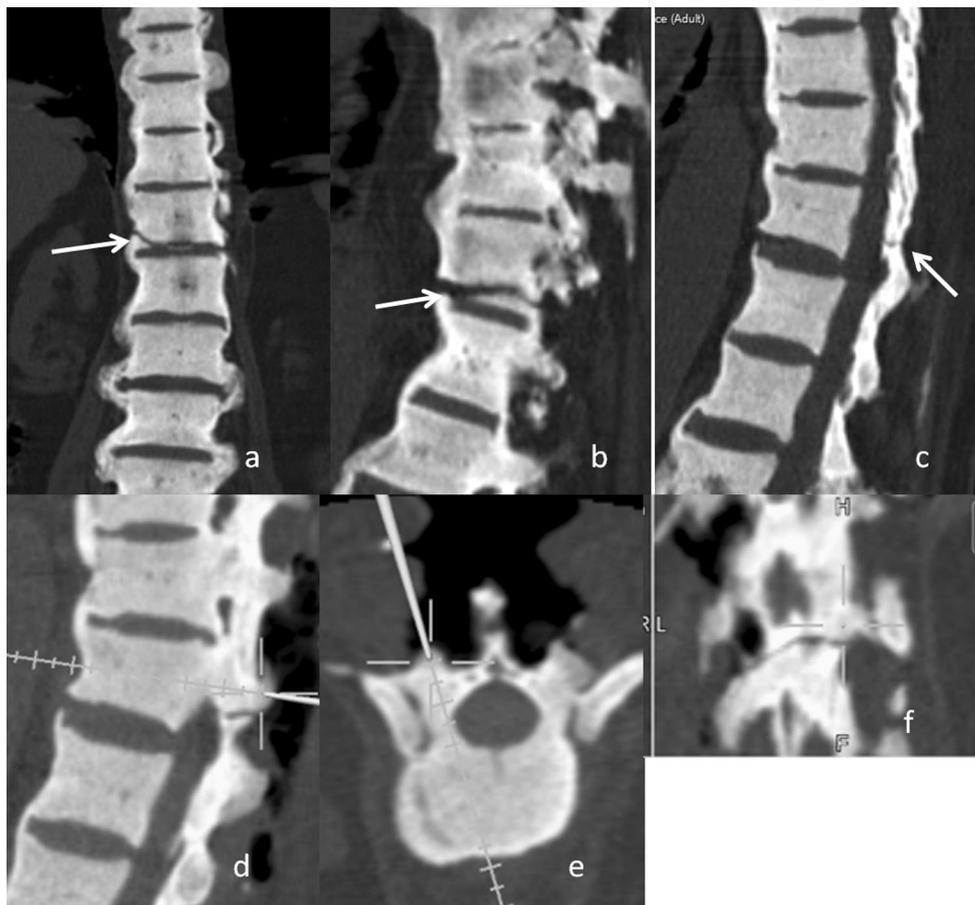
Preoperative CT scan a–c showing fracture line passing through all three columns marked by *arrow* and d–f intra-operative CT navigation images showing fracture line and pedicle tract preparation
